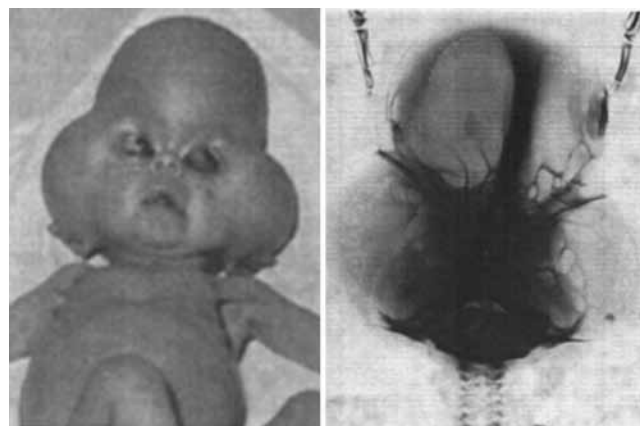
Left: The Kleeblattschädel anomaly. Photograph demonstrating an infant with a cloverleaf skull, or trilobar cranial vault, frontal bossing, pronounced temporal bulging, and exophthalmos. Right: Anteroposterior radiograph demonstrating the constriction band believed to contribute to the formation of a trilobar skull. Both images reproduced with permission from Holtermüller K, Wiedemann HR: Kleeblattschädel-Syndrom. *Med Monatsschr* 14:439–446, 1960.
